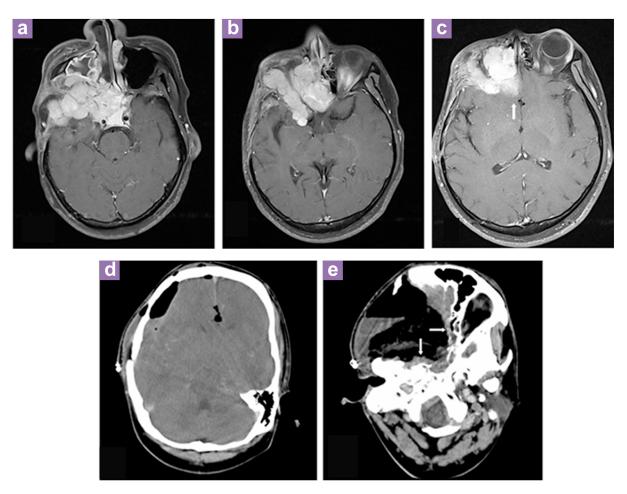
Contrast-enhanced MRI at second admission: A tumour recurrence with extension into the right cavernous sinus, part of the clivus, ethmoid and sphenoid sinuses (2a, 2b). Part of the mass is seen extending into the brain parenchyma with no clear plane in between (2c-arrow). Contrast-enhanced CT after second surgery: Post-operative changes with minimal subdural bleed, fluid collection and cerebral oedema (2d). Fluid is also seen at the right frontal scalp (2d), extending to the right infratemporal fossa (2e). Soft tissue density along the ethmoid sinus and right temporal fossa could represent residual tumour (2e-arrows).
